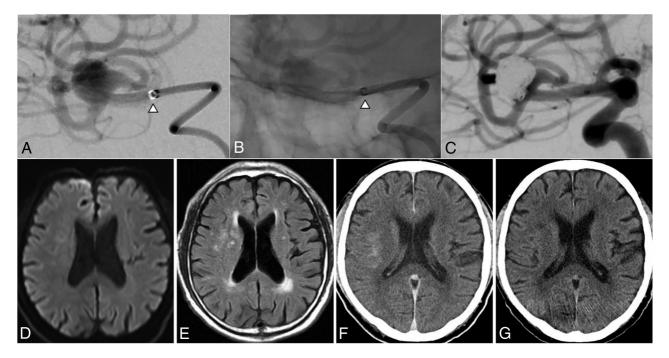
A 70-year-old man undergoing hemodialysis due to end-stage renal failure underwent coil embolization for a right MCA aneurysm with a maximum diameter of 9 mm. Right middle cerebral arteriography (A) and fluoroscopic view (B) show contrast of the right MCA aneurysm from the 6F Sofia catheter, an intermediate catheter guided to the right MCA horizontal segment. Right middle cerebral arteriography (C) shows complete embolization of aneurysm achieved by a stent-assisted technique. Half an hour after completion of the treatment, the patient's condition with stupor, disorientation, and severe left upper and lower extremity paralysis progressively deteriorated. No obvious ischemic and hemorrhagic lesions were seen on MR imaging (D, DWI; E, FLAIR sequence). MRA did not detect arterial occlusion, dissection, or vasospasm. Noncontrast CT (F) shows enhancement due to leakage of contrast medium into the right cerebral cortex and subcortex. After hemodialysis, disturbance of consciousness and left hemiparesis gradually improved. Noncontrast CT (G) 5 days after treatment demonstrates that the contrast-induced enhancement in the right cerebral cortex and subcortex had disappeared. The *arrowhead* indicates the tip of Sofia catheter.
